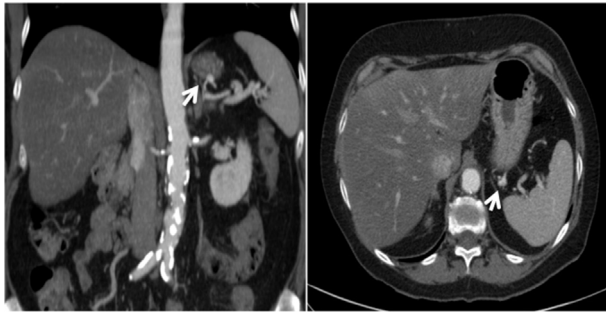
Aneurysm of the posterior gastric artery on computed tomography angiography.
